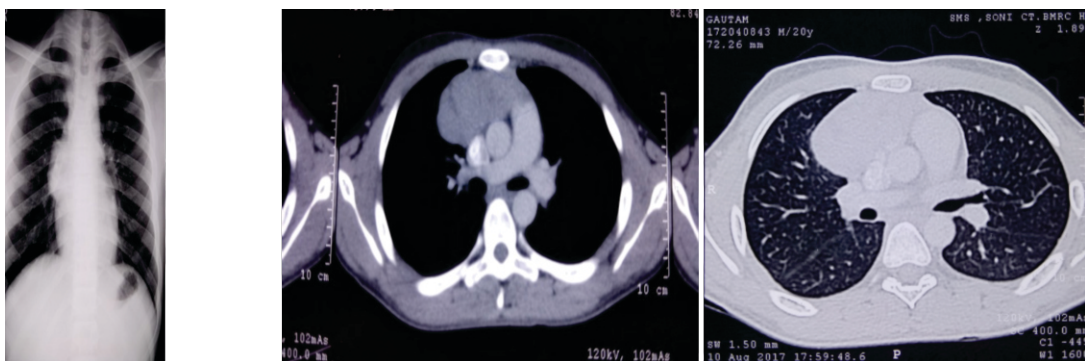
showing preoperative Chest Xray and CT Chest showing anterior mediastinal mass.
